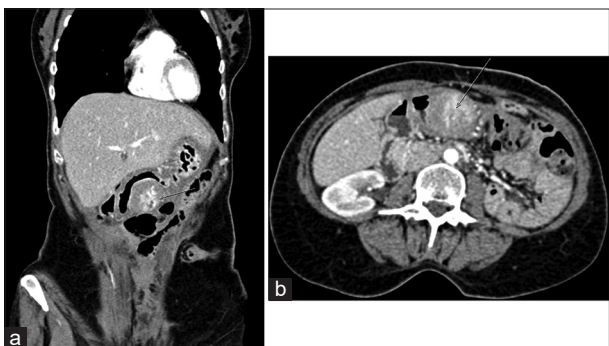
(a and b) A computed tomography scan of the chest, abdomen, and pelvis showing a large, well-defined heterogeneously enhancing serosal mass lesion straddled between distal body and antrum of the stomach with soft calcification within
